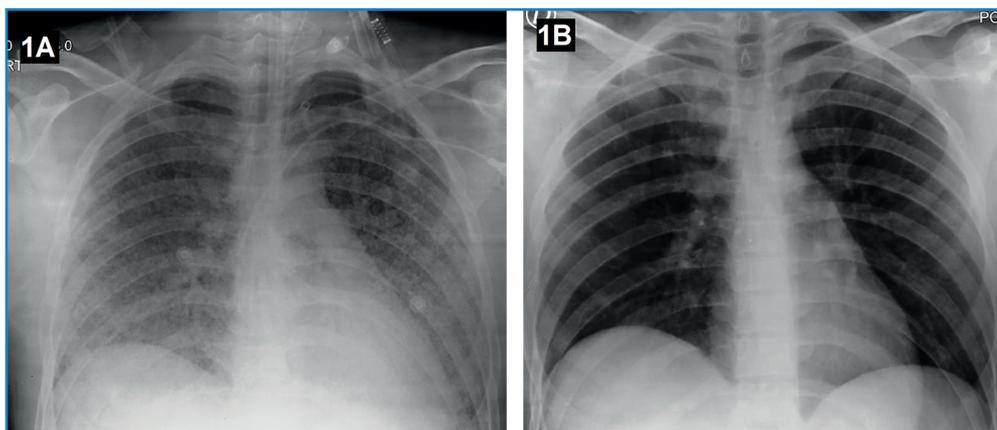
Chest radiograph showing mixed opacities distributed in the parenchyma of all four quadrants of both lungs, without consolidations (A); and complete resolution of the lung infiltrates following treatment (B).
